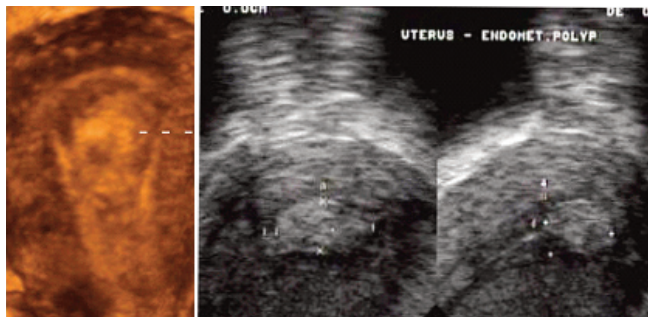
a and b: 3 D and 2 D Ultrasound picture of endometrial polyp
